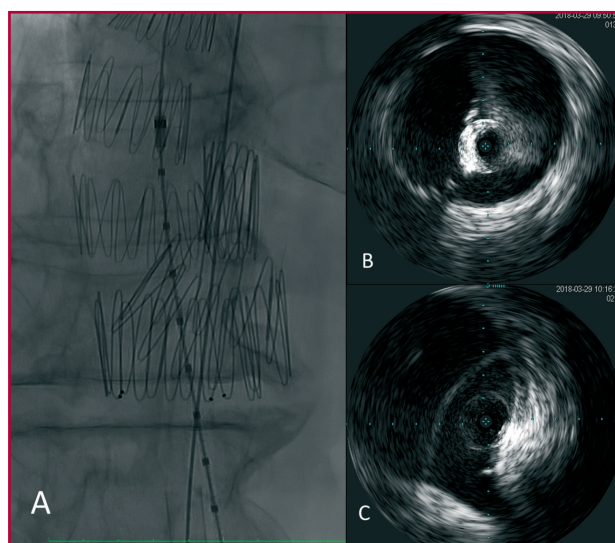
A. Intraoperative angiographic image showing thoracic endograft in the true lumen, and plug (inverted-cup shaped endograft) in the false lumen. B and C. Intravascular ultrasound images both from the true and the false lumen, showing the presence of flow, plug deployment, and celiac trunk origin.
